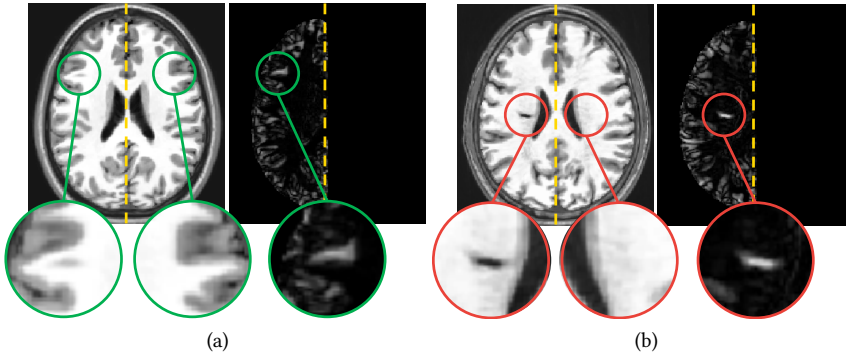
MR images and their corresponding asymmetry maps for (a) a healthy subject and (b) a stroke patient. Green borders indicate examples of pairs of regions with normal asymmetries, whereas red borders indicate abnormal asymmetries resulted from a stroke. The dashed yellow lines show mid-sagittal planes. Normal asymmetries are accentuated on the brain cortex (regions close to the borders). Both cases omit other regions with normal asymmetries.
